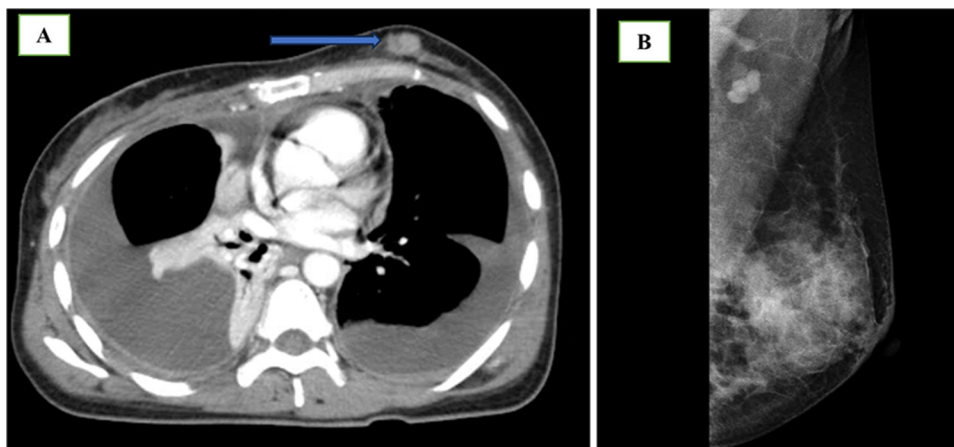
(A). Breast tumor on CT scan before treatment (blue arrow) and (B) breast tumor on mammography.
